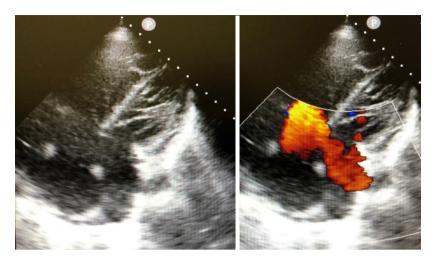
Transthoracic echocardiographic images of a severely ill patient with covid pneumonia and partial atrio-ventricular canal defect (arrow) complicated by significant right ventricle enlargement and pulmonary hypertension, thus exaggerating right to left shunting in a hypoxic patient.
